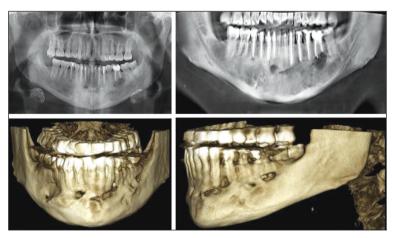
Panoramic radiograph and computed tomography scans after 1 year follow-up of the patient.
